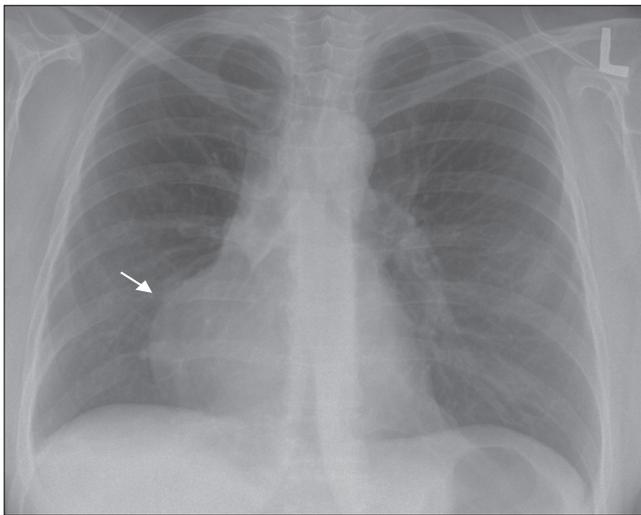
Chest X-ray. Posteroanterior view. Prominent right heart border (arrow)
